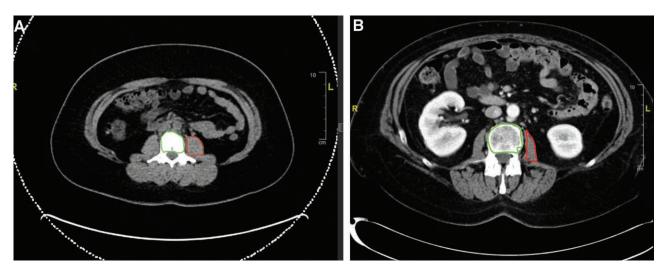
CT scans showing measurement of Sarcopenia. A, Sarcopenia measurements in a patient with an average sarcopenia score with cross-sectional area of the psoas muscle in red and the L3 vertebral body in green. The ratio of red to green, as measured by our PACS softtware, is used to calculate the sarcopenia score. B, Patient with poor sarcopenia score.
